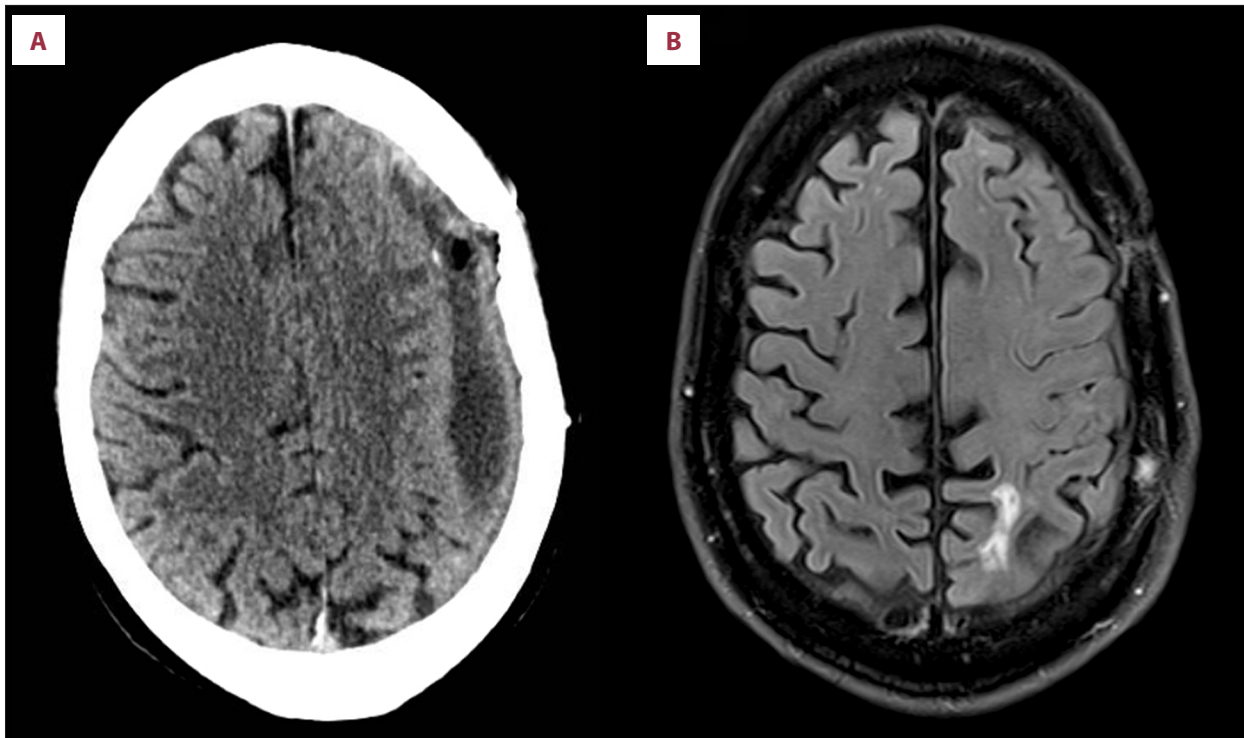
Computed tomography (CT) and magnetic resonance imaging (MRI) following surgery and treatment with tranexamic acid. (A) Computed tomography (CT) scan two weeks after surgery and treatment with tranexamic acid showing a small residual hematoma on the left side. (B) Magnetic resonance imaging (MRI) showing complete resolution of the hematomas, as well as a small parietal ischemic lesion.
